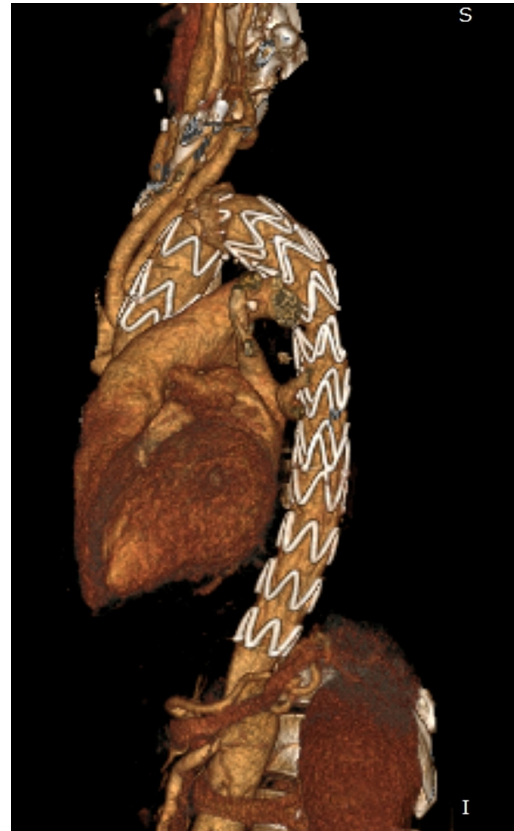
Follow-up CT scan 1 year after surgery.
